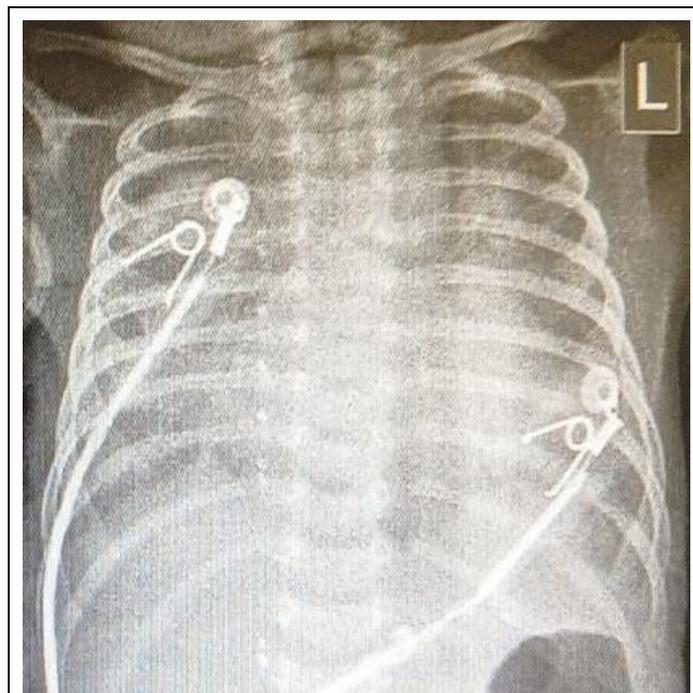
Chest X-ray on second day of hospitalization.
